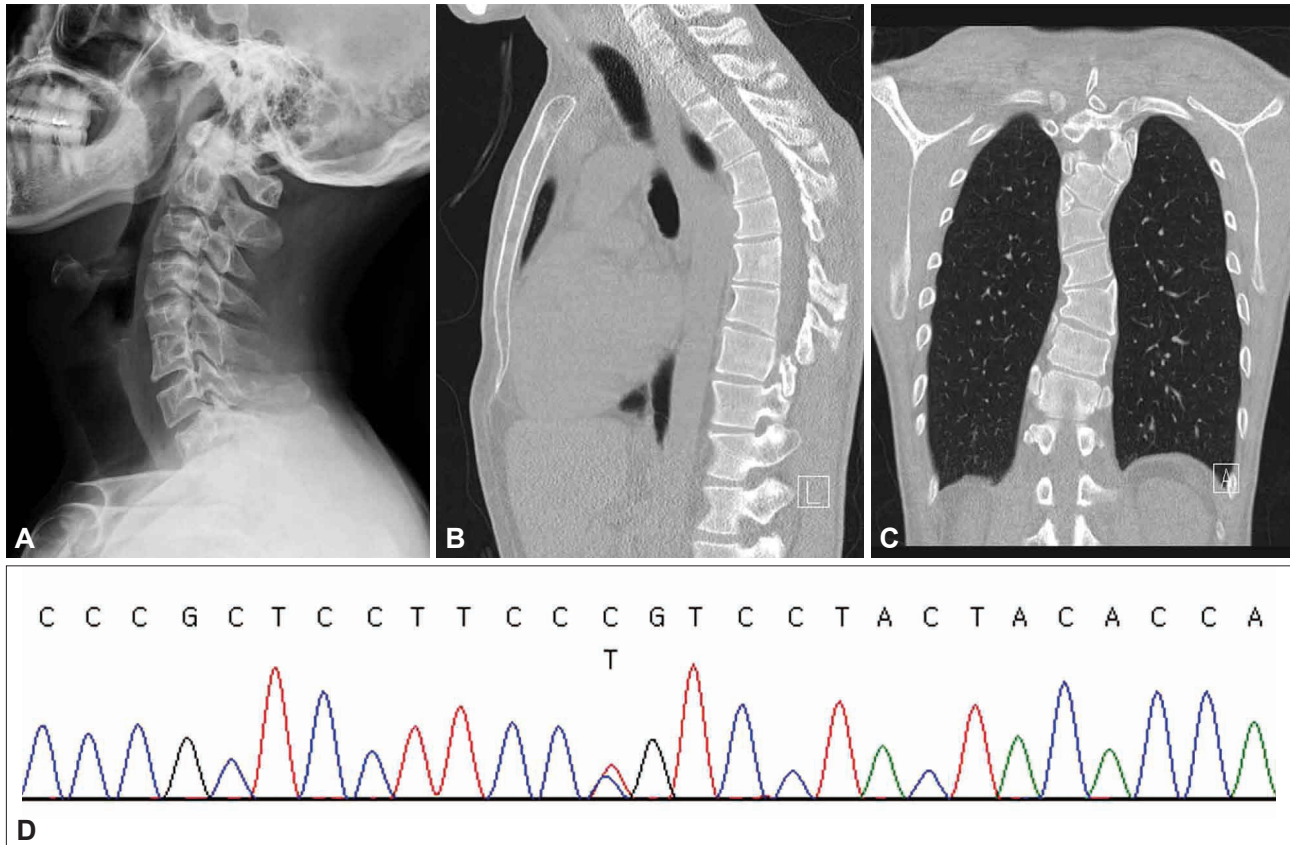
Image study and Sanger sequencing of patient. A: C-spine x-ray. The C-spine x-ray revealed anterior and posterior element fusion of C5-6 and sagittal vertebral clefts of C6, C7 and T1 probably from congenital segmentation abnormality. B, C: Chest CT scan. Chest CT scan revealed benign looking, 4 mm of small nodule in RLL and kyphoscoliosis in his thoracic vertebrae. D: The Sanger sequencing showed heterozygous missense variant c.1319C>T (p.Pro440Leu) in *NEFL* gene.
